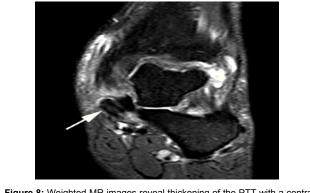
Weighted MR images reveal thickening of the PTT with a central area of high signal intensity consistent with tendinopathy (arrow).
